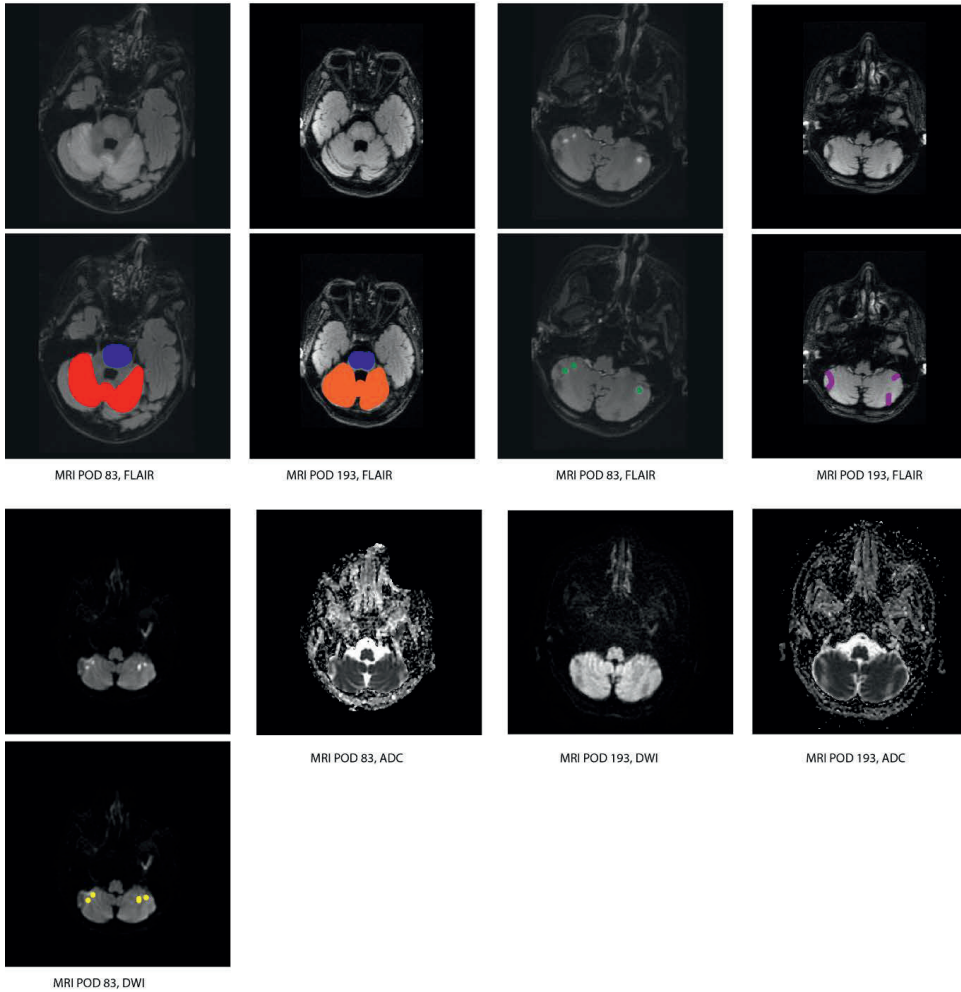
Brain MRI images of the two patients from our center. POD 83= initial MRI or CT-scan and POD 193 = follow-up MRI. T2= T2 weighted images. FLAIR = Fluid attenuated inversion recovery images, acquired after intravenous administration of contrast medium. T1 gado = T1-weighted image after gadolinium administration. 1a = case 1 and 1b = case 2.
